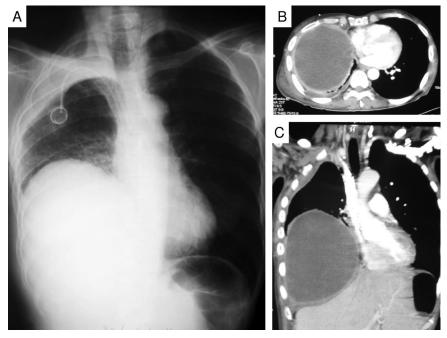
Chest radiograph showing compartmentalized right pleural effusion with pulmonary infiltrates and reduced right lung volume (*A*). Transversal (*B*) and frontal (*C*) chest computed tomography scan slices showing voluminous and compartmentalized right infrapulmonary pleural effusion with mild mediastinal contralateral deviation.
